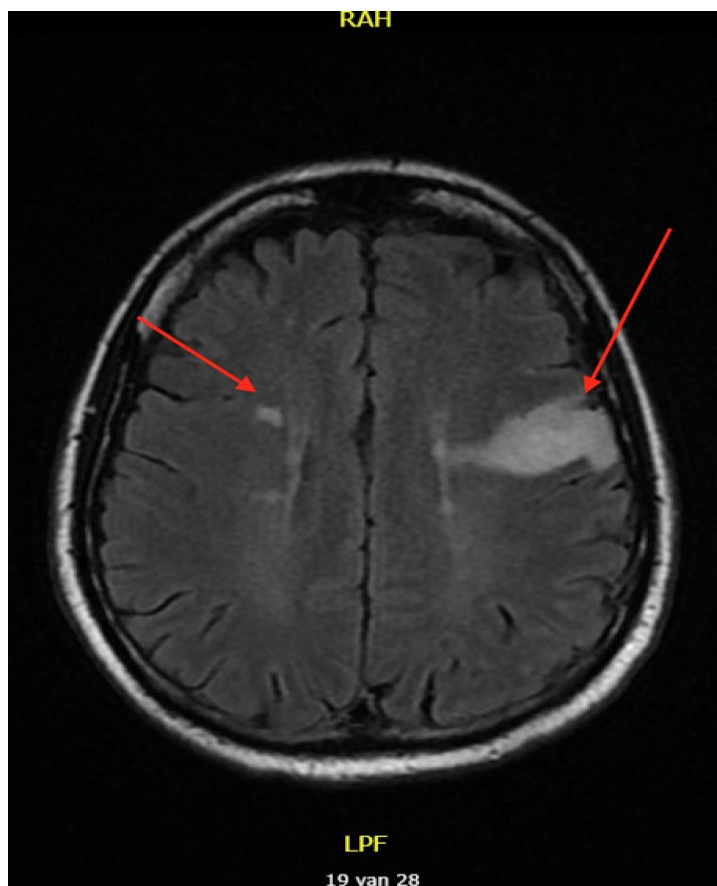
Cerebral MRI showing multiple recent infarctions supra- and infratentorial, probably emboligenic
